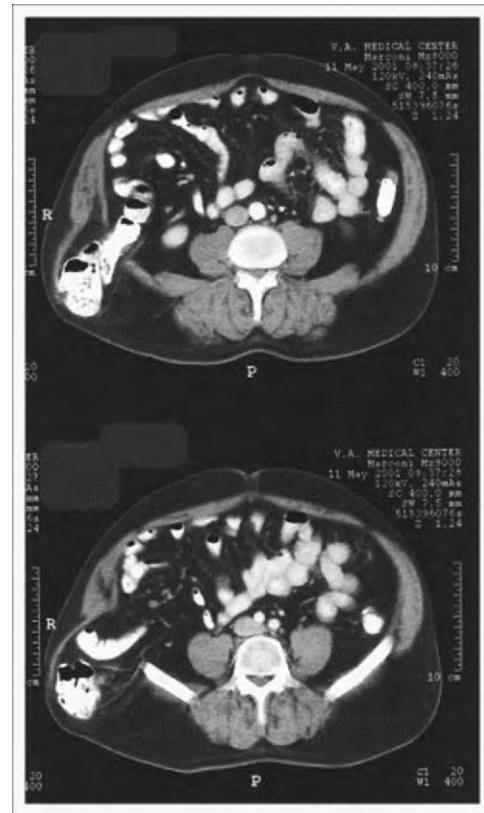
Intravenous and oral contrast-enhanced computed tomographic images of a right inferior lumbar hernia after iliac bone harvest. (From Patten LC, Awad SS, Berger DH, Fagan SP: A novel technique for the repair of lumbar hernias after iliac crest bone harvest. *Am J Surg* 188:85, 2004.)
